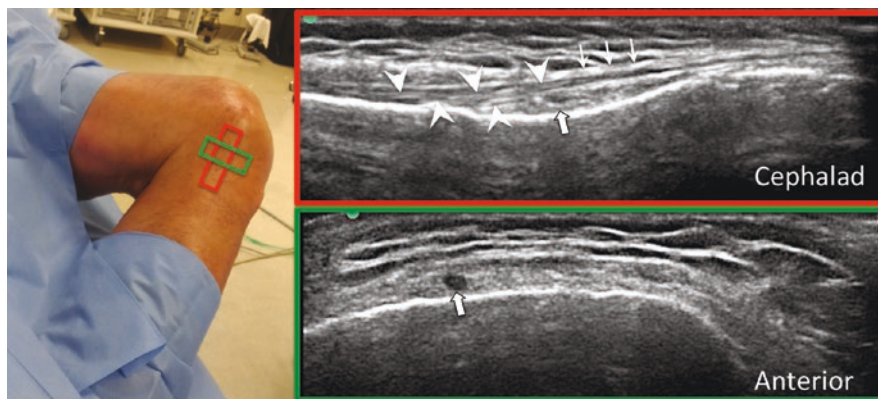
Left panel. The two positions of the ultrasound probe just distal to the epiphysis of the tibia. Right upper panel in red rectangle. The ultrasound probe was in the long axis of the tibia. The inferior medial genicular nerve (IMGN) and vessel (bold arrow) are deep to the medial collateral ligament (arrowheads), which is deep to the crural fascia (arrows). Mark the depth of the bone hyperechoic shadow deep to the IMGN. Right lower panel in green rectangle. The ultrasound was rotated 90 °C and aligned in the cephalad-caudal direction so that the hyperechoic bone shadow is at the same depth as the previous scan. The neurovascular bundle (bold arrow) was seen again. (Reprinted with permission from Philip Peng Educational Series)
